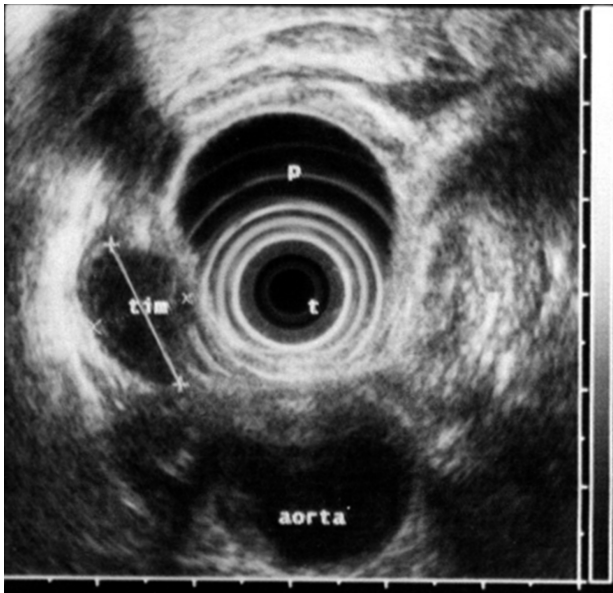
Ultrasound appearance of iuxta-cardial gastric GIST.
